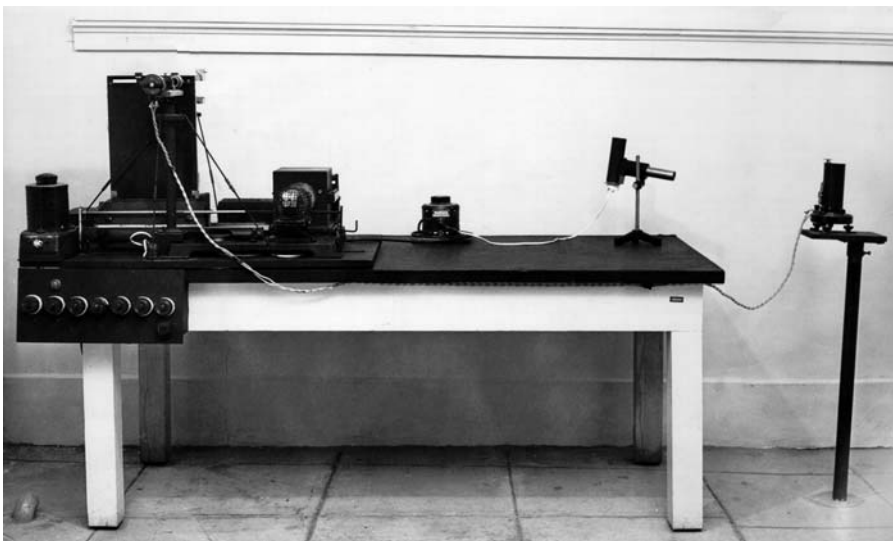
A radiographic photodensitometer at Texas Woman's University from the early 1950s.
